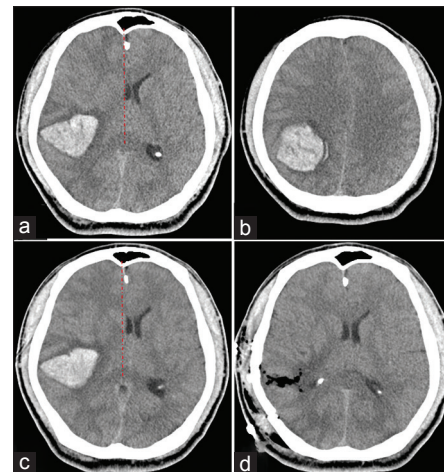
(a and b) First, computed tomography scan revealed right subcortical hematoma. (c) Second, computed tomography scan revealed that hematoma did not expand; however, midline-shift caused by brain edema was slightly worsened. Red dotted lines indicate the median. (d) Postoperative computed tomography revealed complete removal of hematoma
